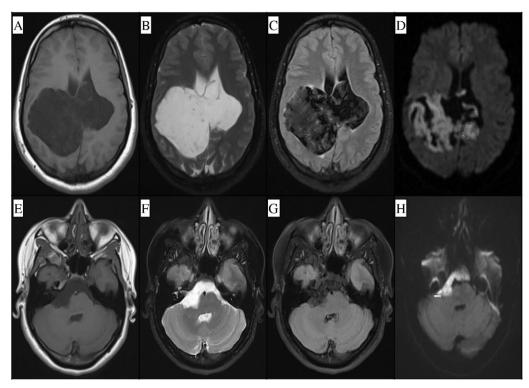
Preoperative T1/T2/FLAIR/DWI images for patient 1 (A–D) and patient 2 (E–H).
